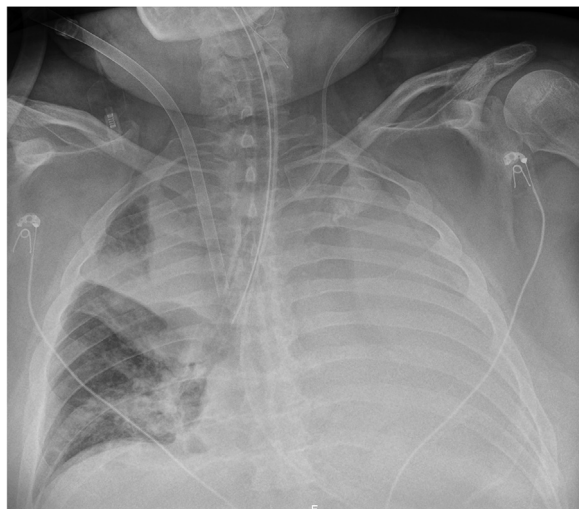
Chest X-ray showing selective intubation, venovenous extracorporeal membrane oxygenation cannulas in the right internal jugular vein, and diffuse atelectasis of the right lung multiples lobes and complete atelectasis of the left lung.
